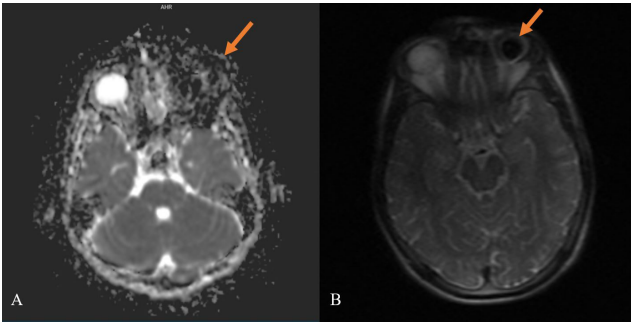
Diffusion magnetic resonance images in the axial plane showing typical magnetic susceptibility artifact (orange arrows) obscuring the anatomical structures of the left orbit and surrounding regions
